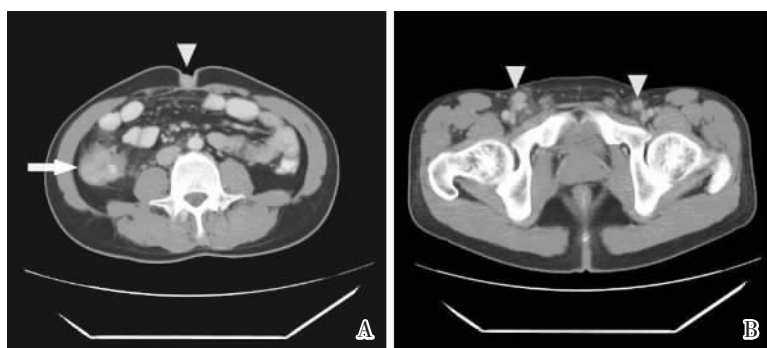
CT scans of the abdomen and inguinal regions of a 37-year-old man with right colon cancer accompanied by Sister Mary Joseph's nodule and inguinal nodal metastases
